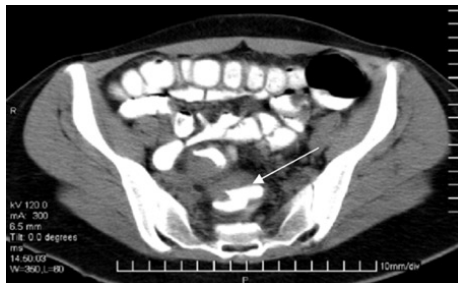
CT scan showing recto-sigmoid narrowing.
